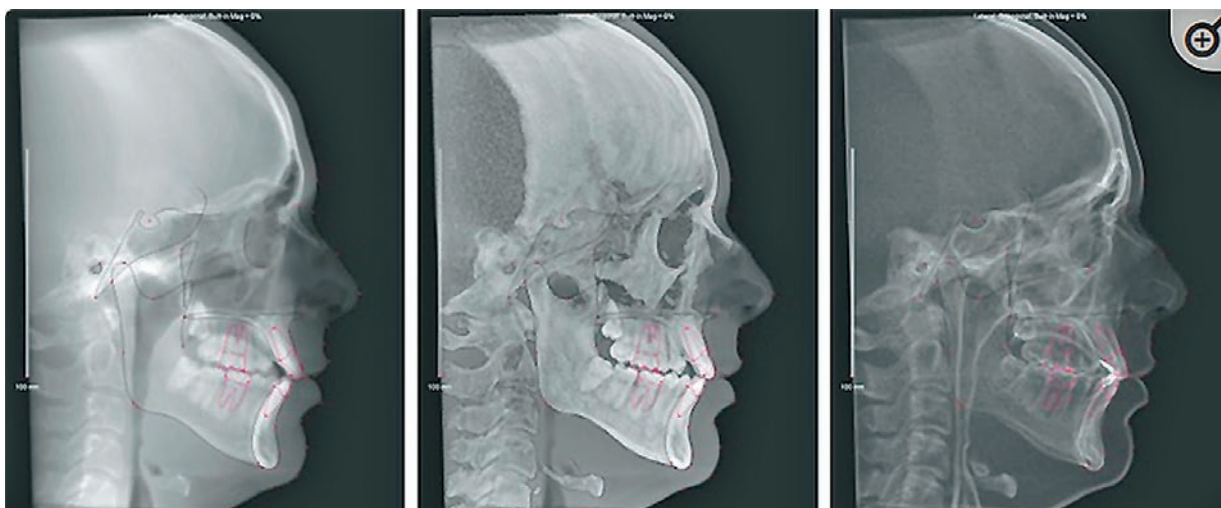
Different types of filters offered by CBCT cephalogram processing software
